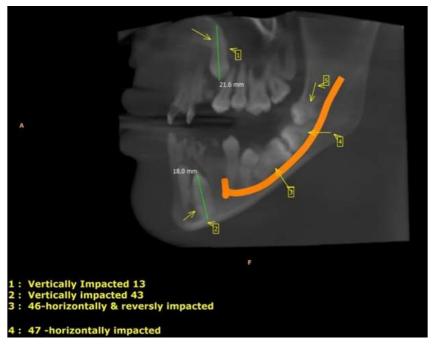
Sagittal section of CBCT showing impacted and retained teeth
